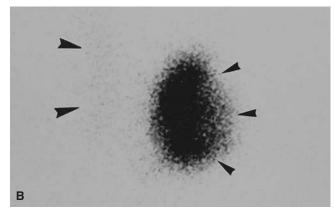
Patient with an autonomously functioning or "hot" thyroid nodule. *A*, Sonogram of thyroid showing a 3.6×2.1 cm mixed echogenic nodule (*arrowheads*) occupying almost the entire left lobe. *B*, Radioactive iodine (¹³¹I) thyroid scan showing intense tracer uptake by the nodule (*small arrowheads*) with suppressed tracer uptake in the right lobe (*larger arrowheads*). Courtesy of E. S. Ang, MD, Department of Nuclear Medicine, Singapore General Hospital, Singapore.
